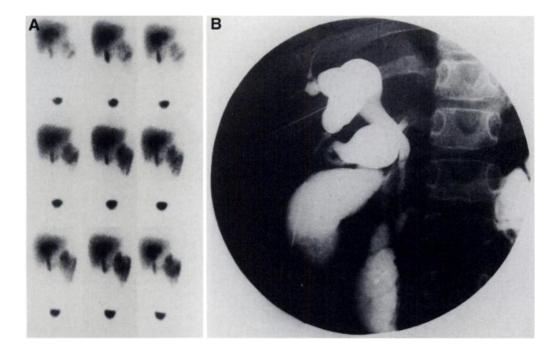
Large choledochal cyst. A 10-mo-old female infant presented with jaundice. Hepatobiliary scintigraphy (A) revealed marked dilatation of the main right and left hepatic ducts, upper common bile duct and cystic duct but tracer passed into the duodenum. Percutaneous cholangiogram (B) confirms the marked dilatation of the main hepatic ducts, cystic duct and upper common bile duct.
